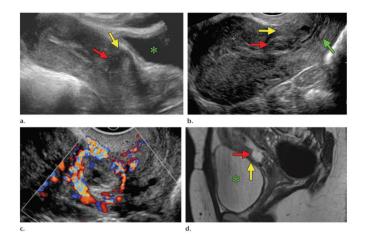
Ectopic pregnancy in cesarean scar. (a) Sagittal transabdominal grayscale US image in a patient with a previous cesarean section shows a gestational sac (red arrow) on the anterior wall of the lower surface of the uterus anterior to the bladder (\*), with thinning of the myometrium (yellow arrow) seen anteriorly to the bag (b) Sagittal transvaginal US image shows the tapered myometrium (yellow arrow) anterior to the gestational sac (red arrow), which is above the closed internal cervical os (green arrow). Note the empty endometrial cavity (between the calipers). (c) Sagittal transvaginal color Doppler image showing peritrophoblastic flow around the gestational sac. (d) Sagittal T2-weighted magnetic resonance image shows the gestational sac (red arrow) in the lower anterior uterine segment and the tapered myometrium (yellow arrow) between the gestational sac tional sac and the bladder (\*)<sup>5</sup>
